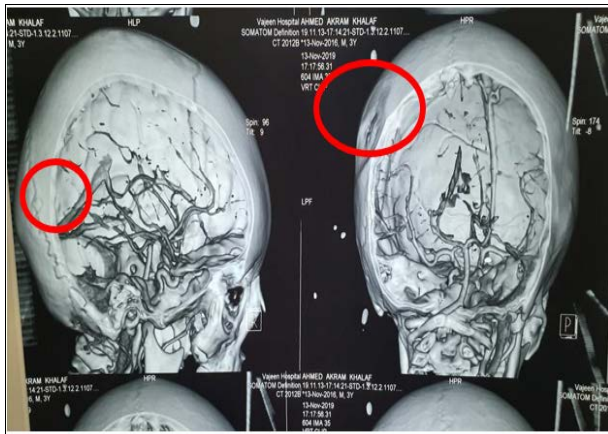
CT angiography of the mass showed the site of connection extracranial with intracranial
